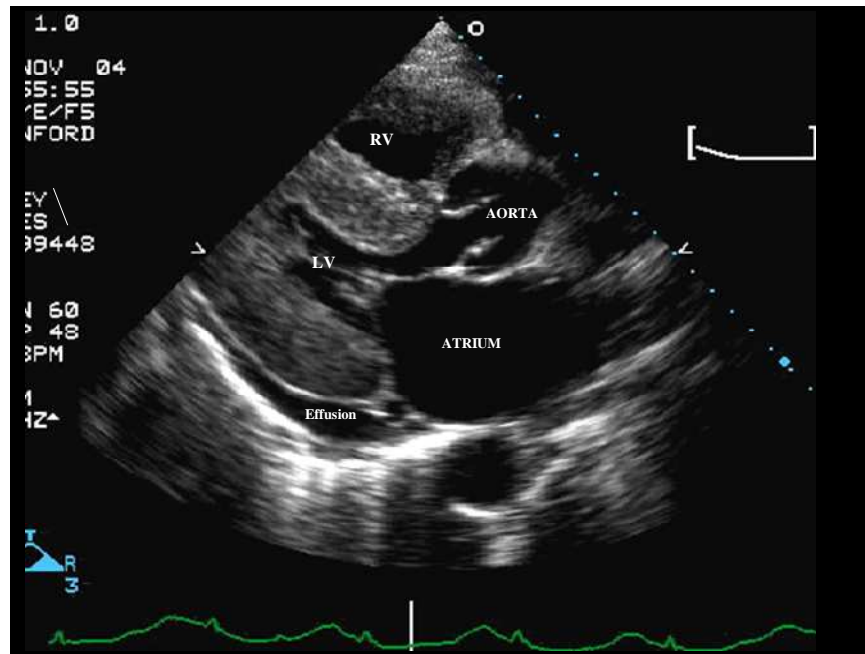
Echocardiographic Findings of Cardiac Amyloid (Courtesy of R. Falk, MD) A parasternal long-axis view in a patient with severe cardiac amyloidosis. The LV walls are thickened and echogenic. The left atrium is enlarged. The aortic valve is particularly well seen due to infiltration.
